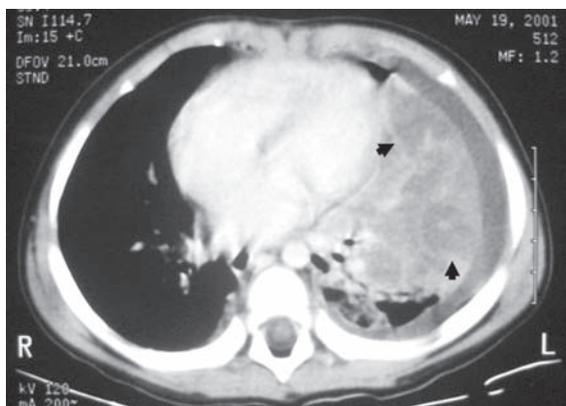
Computed tomography scan of the chest obtained at the same time showing lobar pulmonary liquification with multiple decreased parenchymal enhancements (black arrow). Subsequent plain chest radiograph showing multiple small lucencies with cavitation formation confirmed the diagnosis of necrotizing pneumonia (NP).
